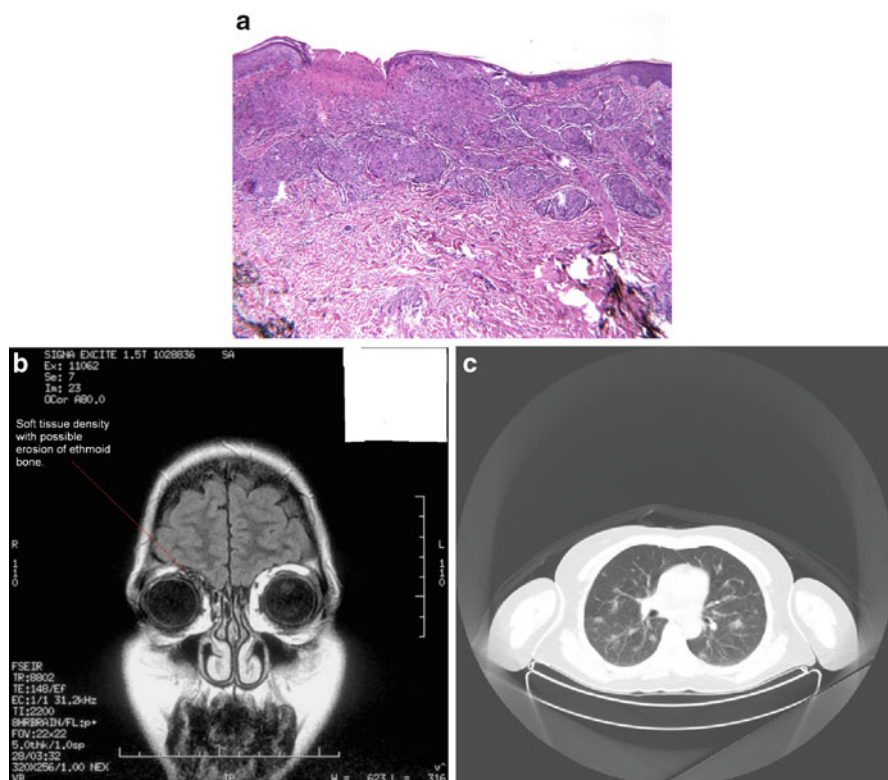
(a) Dermatopathology of the skin rash. (b) MRI with T1 weighted image showing soft tissue density on the medial side of the right orbit. (c) CT chest demonstrating bilateral nodular infiltrates
